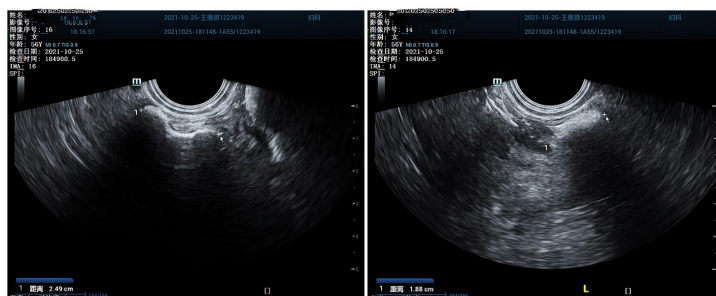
The dotted line indicates an irregular arc. The left side of the sonogram is from the left side of the posterior vaginal wall, and the right side of the sonogram is from the right side of the posterior vaginal wall
